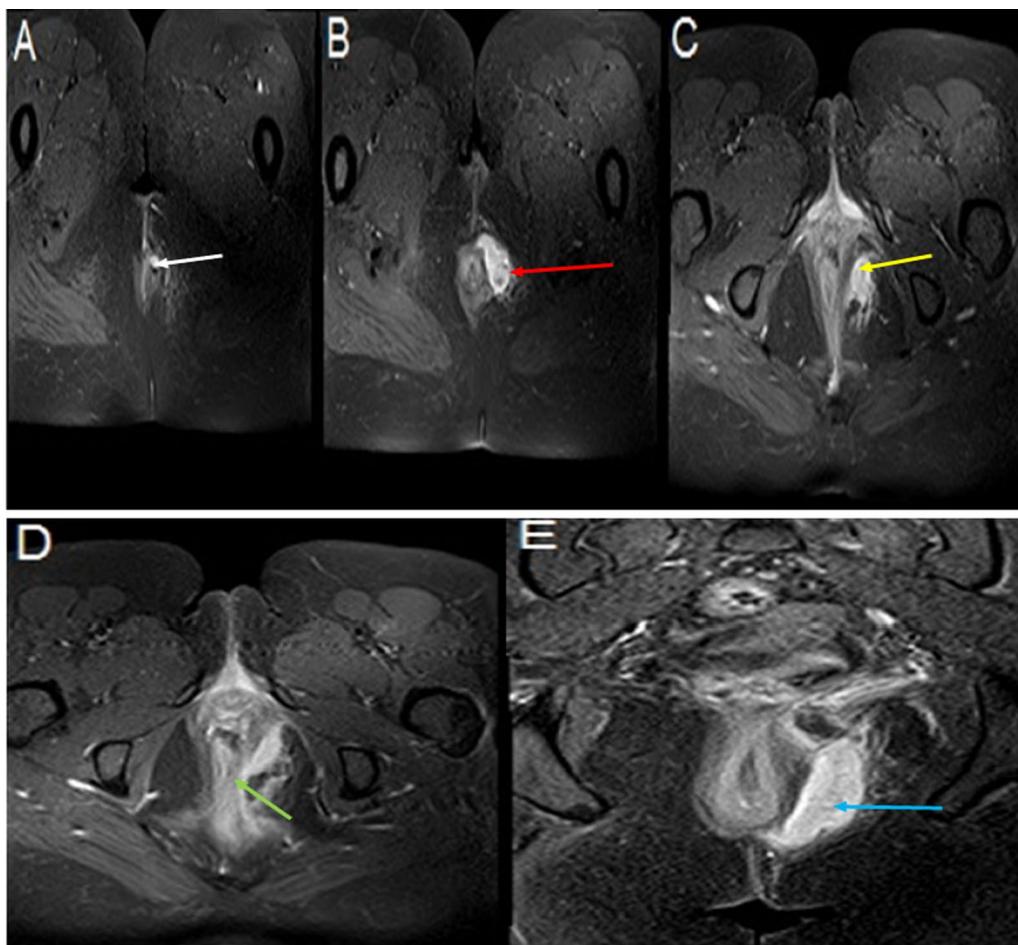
A 35-year-old female patient presented with left perianal discharge. She was diagnosed clinically with a perianal abscess. Therefore, from the start, we injected IV contrast material. MRI examination after IV contrast injection revealed in enhanced axial T1 FATSAT images (A–D): A External cutaneous opening of the fistulous tract in the left perianal region (white arrow). B Distended cavity with peripheral enhancement at the left ischioanal fossa denoting abscess formation (red arrow). C An abscess ascending upward and piercing the left levator ani muscle with supralelevator extension (yellow arrow). D Internal mucosal opening at the anorectal junction at four o’clock (green arrow). E Enhanced coronal T1 FATSAT image shows the course of the left extrasphincteric fistula (blue arrow). The final diagnosis was a left, grade V, extrasphincteric fistula
